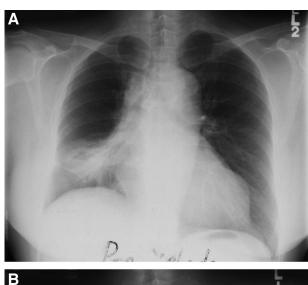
Chest radiographs of the index patient (case 2) with durable disease stabilization to capecitabine treatment for LELC of lung: (A) at baseline before capecitabine treatment (right middle lobe tumor measured 4.5 \times 3.5 cm); (B) 3 months after capecitabine treatment (right middle lobe tumor measured 4 \times 3.5 cm); and (C) 6 months after capecitabine treatment (right middle lobe tumor measured 4.2 \times 3.5 cm).
